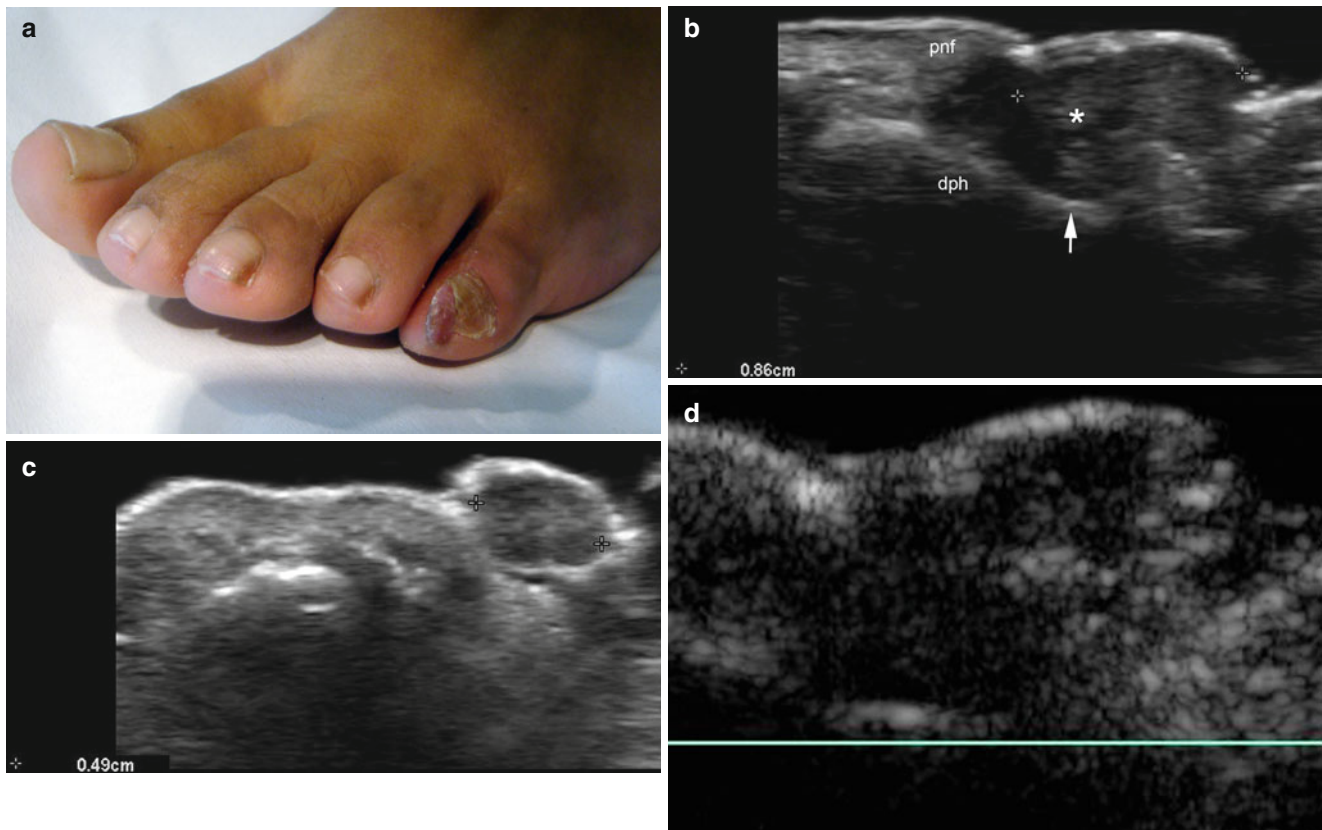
(a–d) Subungual and periungual fibroma. (a) Clinical image shows a periungual reddish bump in the medial aspect of the left fifth toenail. (b) Grey scale ultrasound image (longitudinal view) shows a 8.6 mm long subungual hypoechoic solid structure (*, between markers) that remodels the bony margin (*arrow*) of the distal phalanx. (c)
